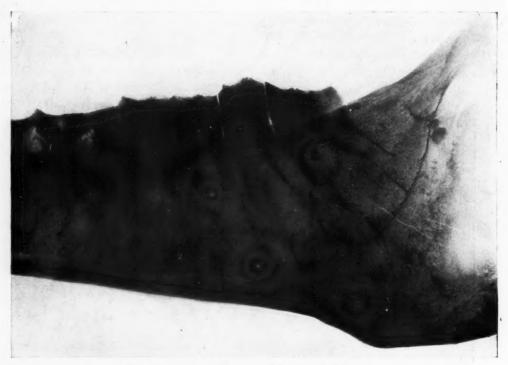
Radiograph of mandible of an old borse.
